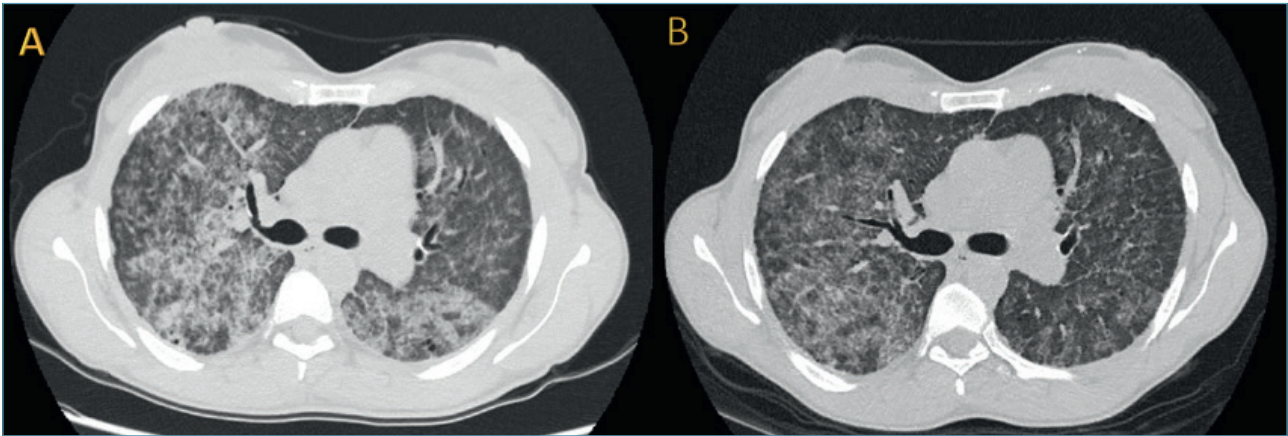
A) Thorax HRCT shows bilateral “crazy paving” pattern with small pulmonary consolidation opacities. B) Thorax HRCT after bilateral whole lung lavage treatment: note the reduction of “crazy paving” pattern and consolidation area.
